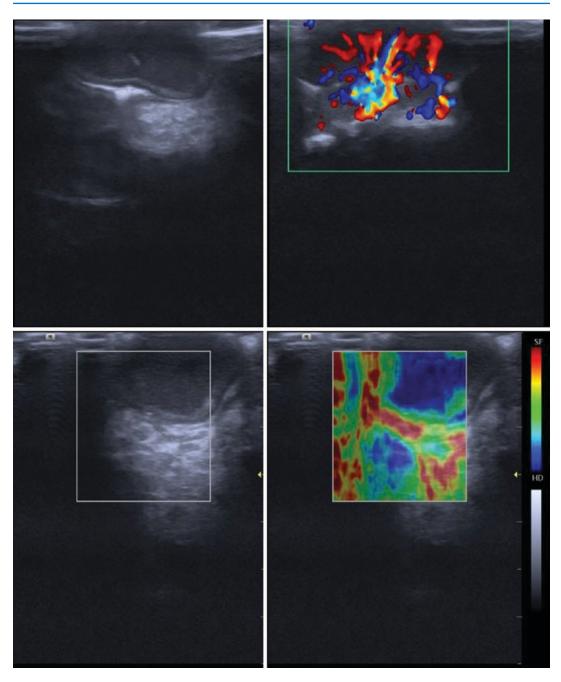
Peripheral giant cell granuloma. (a) US reveals a unilocular, well-defined lesion with a predominantly hypoechoic internal structure. Heavy acoustic enhancement is seen. (b) Doppler US reveals increased
